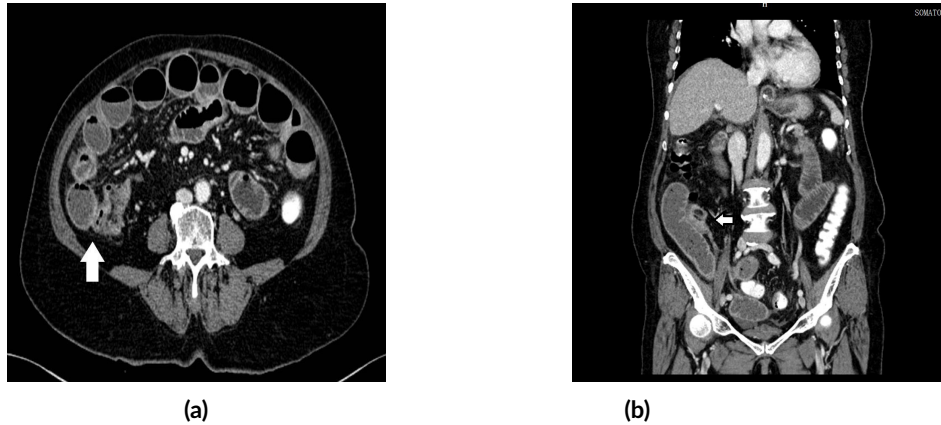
shows CT abdomen (axial and coronal view). Arrow indicates the suspicious mass at the distal ileum with dilatation of the small bowel. There is an abrupt transition at the narrowed of terminal ileum due to obstruction in the small bowel.
